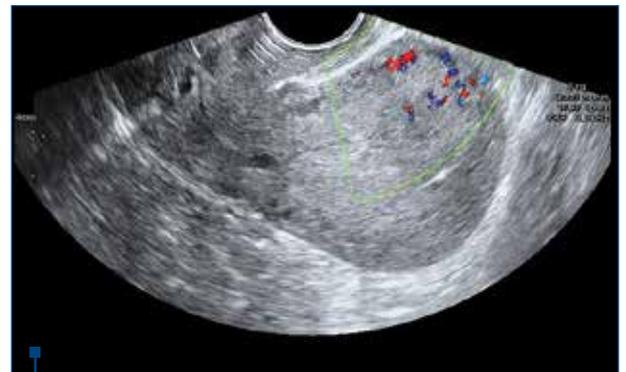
Ultrasound examination of the 29-year-old patient presented in Figure 1 after the embolization
